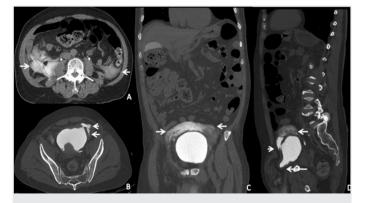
(A-D) Non-contrast enhanced computed tomographic images. There is an extravasated contrast material to both the paracolic gutters and retroperitoneal area (short arrows). (B,D) At the left anterior wall of the bladder, there is a defect and contrast material extravasated through the side (arrowheads). (D) A large inguinal defect with a herniated portion of the urinary bladder (long white arrow)
